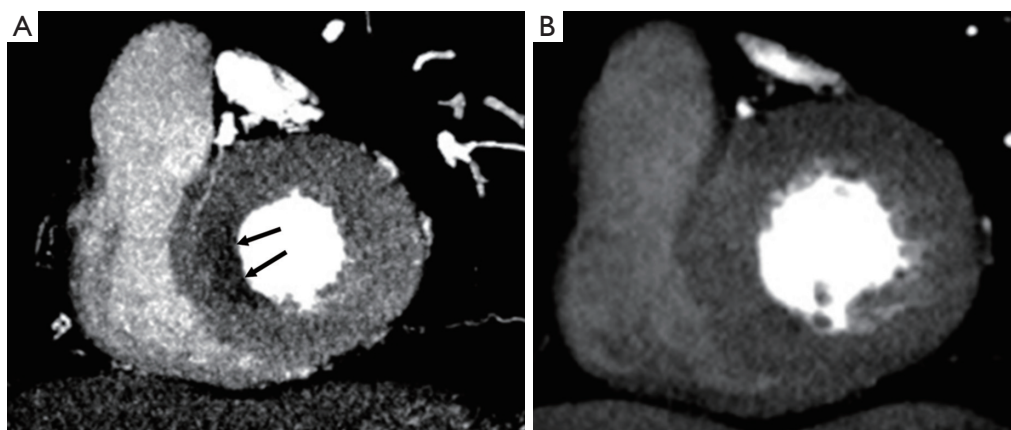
CT perfusion. (A) Short axis stress perfusion CT image obtained at 45% of R-R interval in a patient with chest pain, shows a sub-endocardial perfusion defect in the basal septum (arrows); (B) rest CT perfusion image in the same patient at the same level does not show the defect. These findings are consistent with reversible myocardial ischemia. CT, computed tomography.
